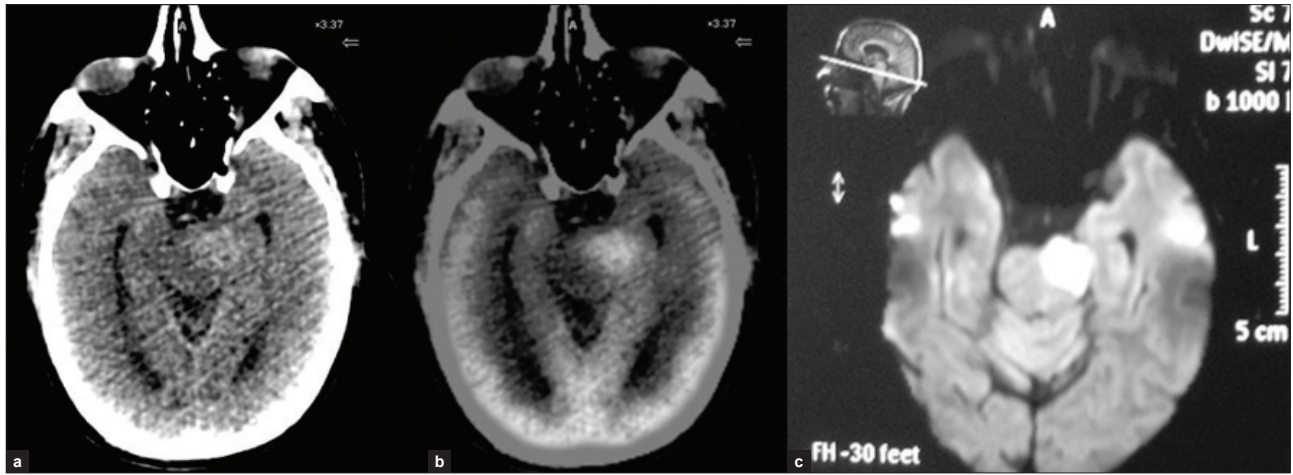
73-year male Ca lung post CT/RT with history of stroke three weeks back; (a, b) Axial LDCT and fused PET/CT images showing an area of hyper-metabolism corresponding to a hyper-dense lesion in the pons left side; (c) DW MR images show hyper-intense signal and ADC IMAGES showed hypo-intense signal s/o acute infarct
